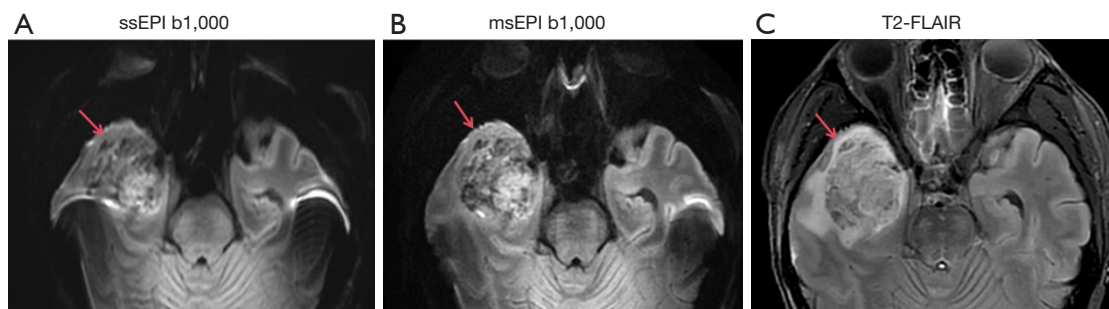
A 34-year-old male patient with high-grade glioma. (A) The glioma lesion (red arrow) on ssEPI DWI. (B) The meningioma lesion (red arrow) on msEPI DWI. (C) The meningioma lesion (red arrow) on T2-FLAIR. The glioma lesion appeared less distorted and had a clearer internal structure on msEPI DWI than on ssEPI DWI. ssEPI, single-shot echo-planar imaging; b1,000, $b=1,000 \text{ s/mm}^2$; msEPI, multishot echo-planar imaging; T2-FLAIR, T2-weighted fluid-attenuated inversion recovery; DWI, diffusion-weighted imaging.
